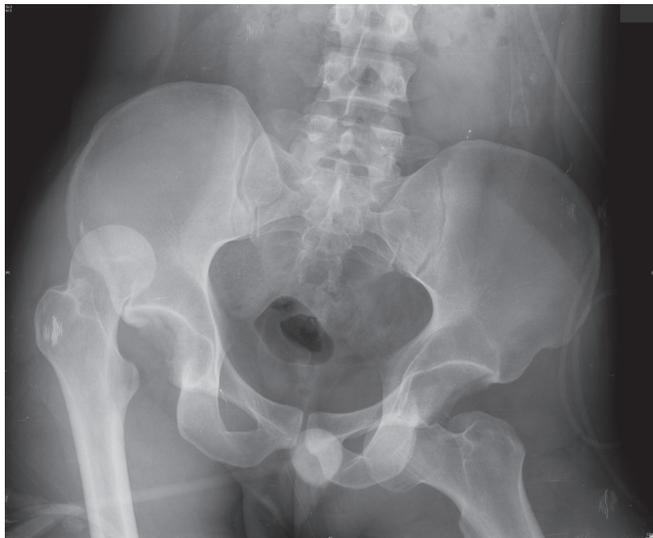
Plain radiographs of the pelvis.
